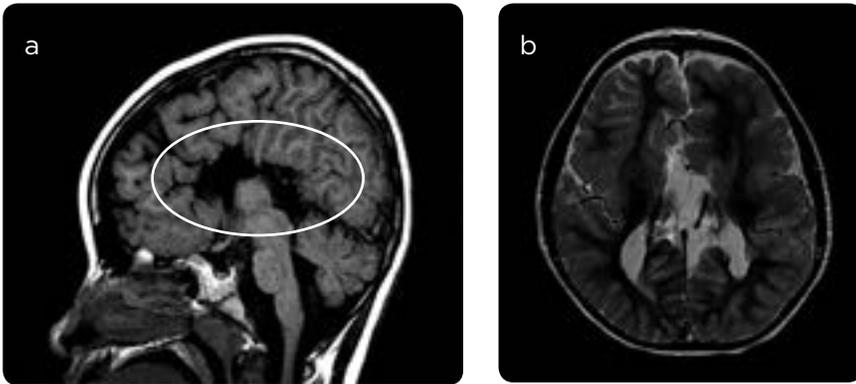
a) Sagittal MRI, T1 sequence FLAIR: complete absence of the corpus callosum is observed. b) Axial MRI with T2 information: complete absence of the corpus callosum.
